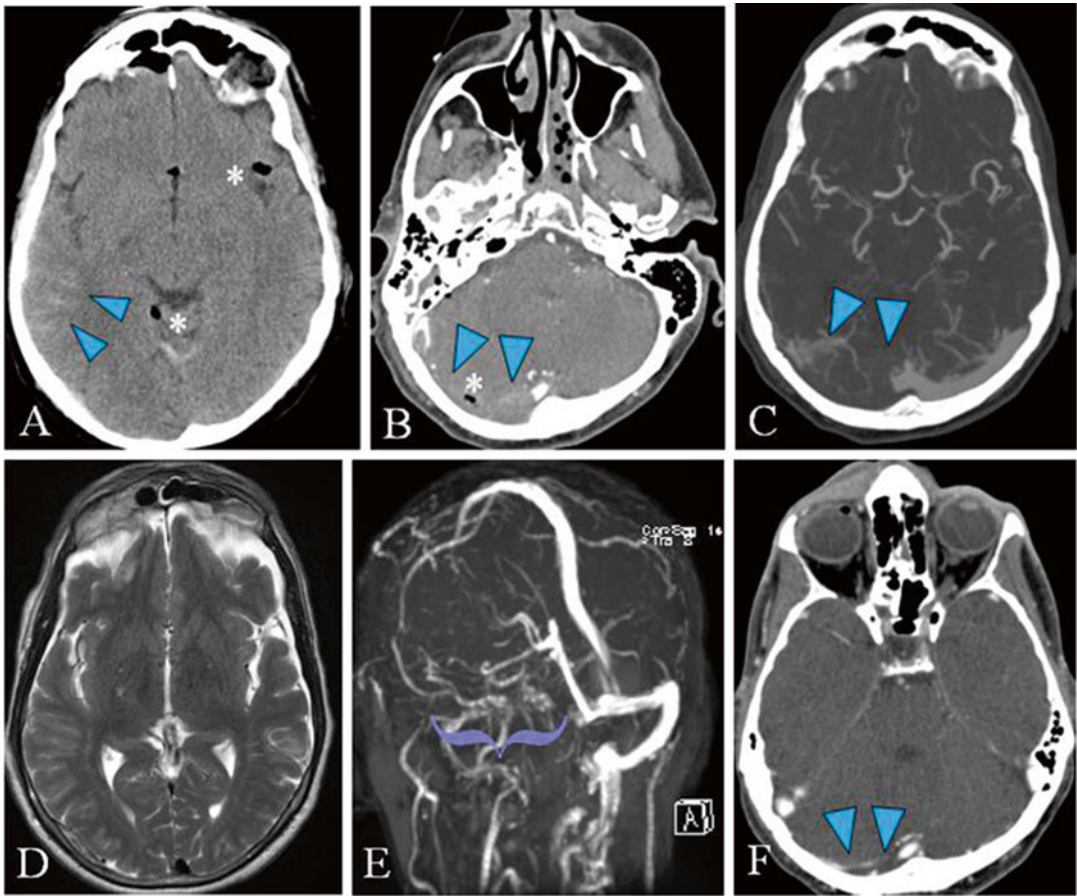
Case III: A man with a history of seizures, CVST and a recent trauma. A 54-year-old left-handed male presented after a fall from standing 1 day prior to admission. He was amnesic to the event but thinks he may have slipped on some gravel. He hit the back of his head on the ground. He was neurologically intact on presentation but had right posterior parieto-occipital scalp bruising and bilateral racoon eyes (R>L) and right Battle's sign. He reports headache but denied nausea, vomiting, or confusion. He did have a generalized tonic-clonic seizure 2 weeks prior. An initial non-contrast head CT head (a and b) obtained for rapid evaluation in the setting of trauma. It showed trace right temporal-parietal subarachnoid hemorrhage (a—arrowheads), a transverse fracture of the right temporal bone with extensive pneumocephalus (a—asterisk) intracranially as well along the right transverse and sigmoid sinuses (b—arrowheads and asterisk) as well as the right jugular fossa. These findings were concerning for sinus involvement and a CTA/CTV
